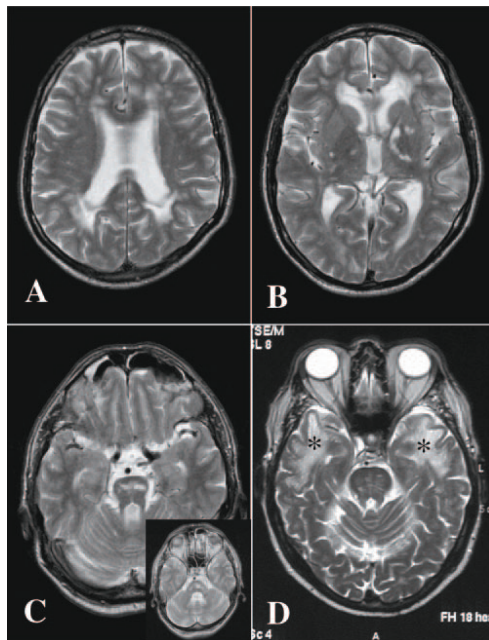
Axial MR images of an affected subject from the Swedish family with hereditary MID and a CADASIL patient. (A) T₂-weighted MR image at the level of basal ganglia showing periventricular hyperintensities in the 'caps' of the ventricles. Infarcts were also evident in left putamen. (B) MR image at the level of thalami with more lesions evident in the basal ganglia. (C) (and inset), MR images showing lack of hypersignals in the temporal poles and no profound lesions in basal part of brain. There were no clear hypersignals in the temporal horns comparable to those in CADASIL. (D) For comparison note high signal in white matter of temporal poles in the 61-year-old CADASIL patient.
